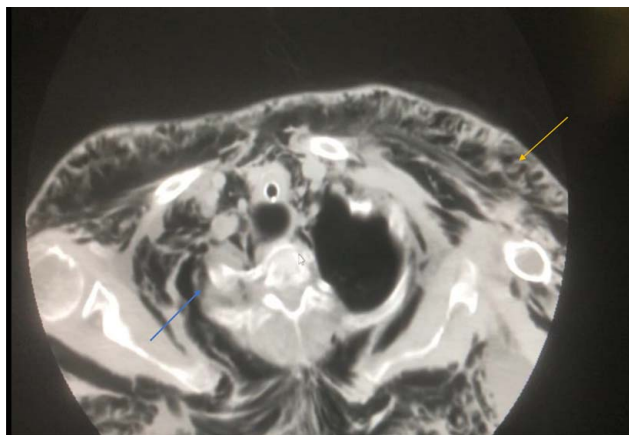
Thoracic computed tomography reveals subcutaneous emphysema and pneumomediastinum.
